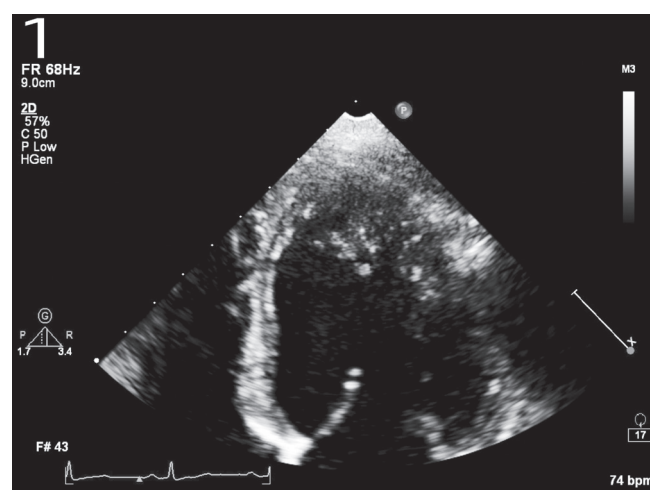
Apical four-chamber view in diastole demonstrating marked trabeculation of the apex and apicolateral wall.
